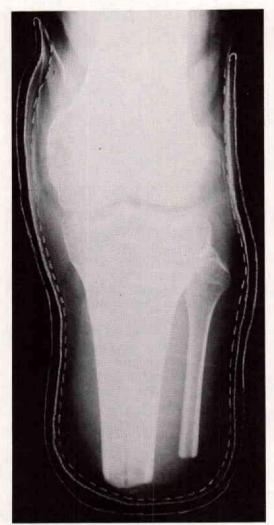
Anteroposterior view reflects mediolateral relationship of stump to socket. X-ray is outlined for clarity of interfacing and socket shell.
